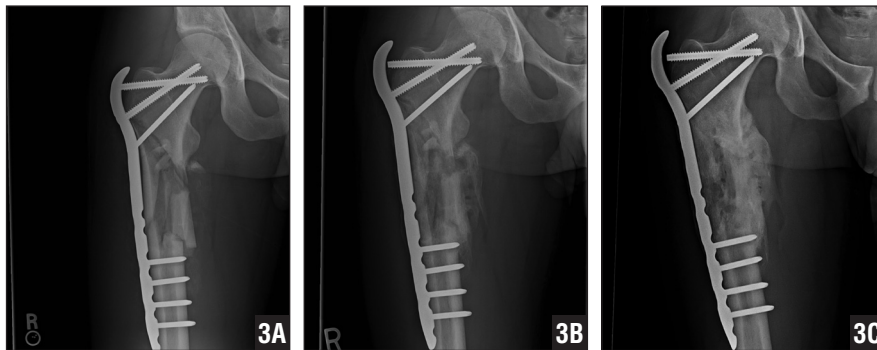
Patient 13. Postoperative anteroposterior radiograph at 2 weeks (A), 2 months (B), and 6 months (C) showing proximal screw breakage but a healed fracture at final follow-up.
